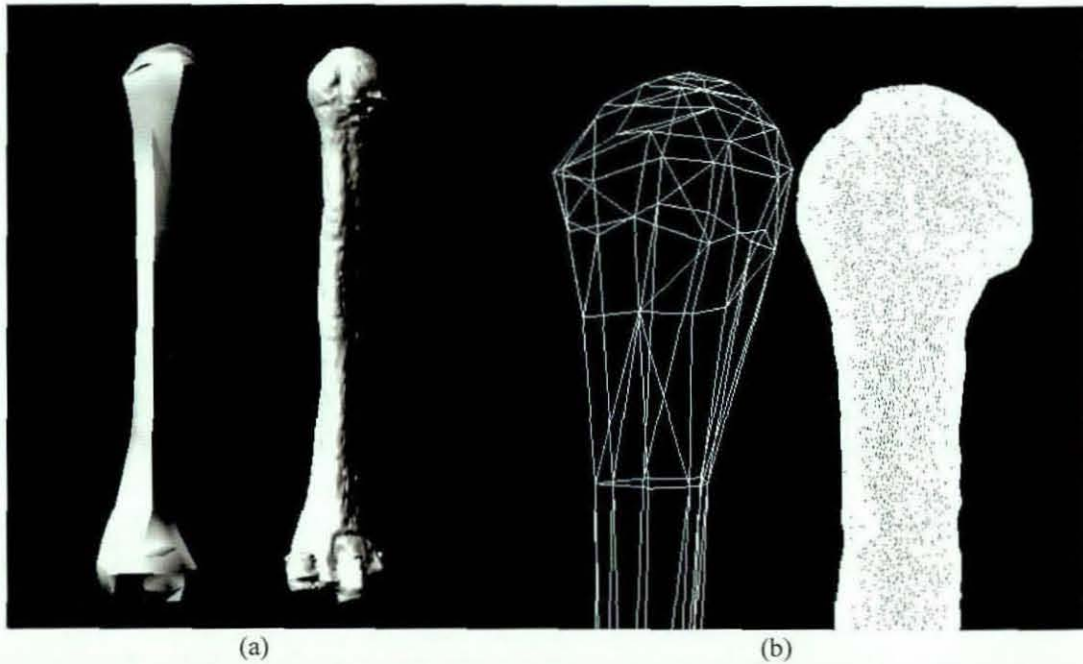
The comparison of the rendered surface image of the humerus (a) and a surface mesh of the humeral head (b) found from the literature (left) and obtained from the MRI scan (right)
